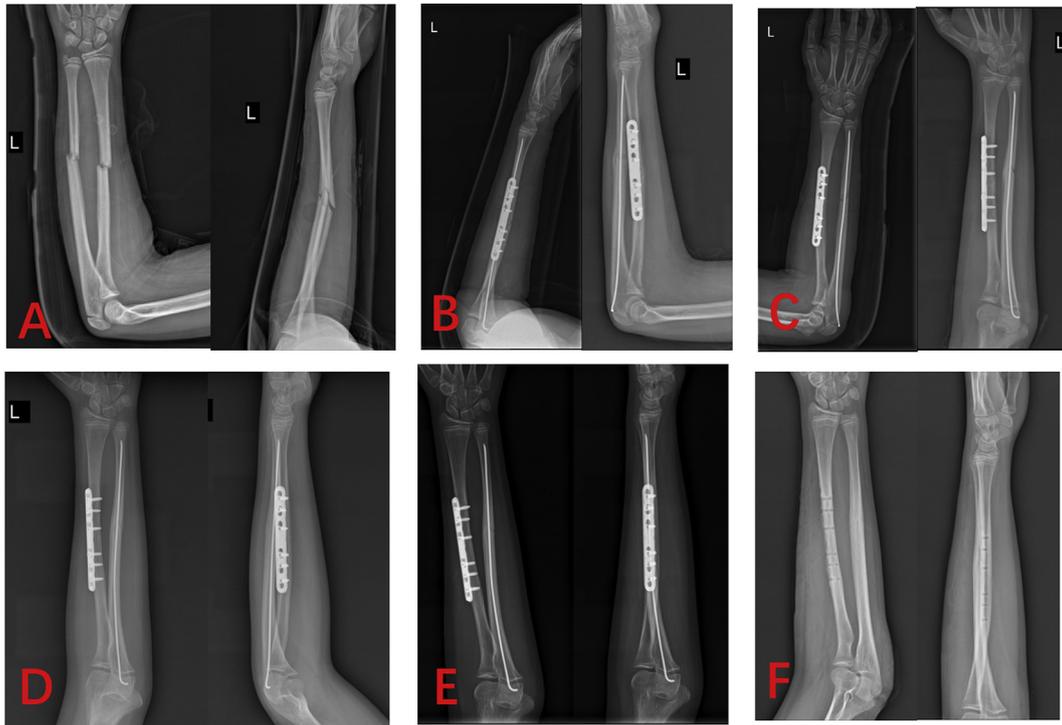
A 13-year-old boy sustained forearm fracture in a falling accident with treatment of hybrid fixation construct with elastic intramedullary nailing of the ulna and plate fixation of the radius. A: preoperative anteroposterior and lateral radiographs of the forearm showing a fracture of the upper third of the radial and ulnar shaft. B: X-ray after surgery with cast. C: X-ray of one month after surgery. D: X ray of three months after surgery, fracture union. E: X ray of five months after surgery. F: X ray of removal the hardware.
